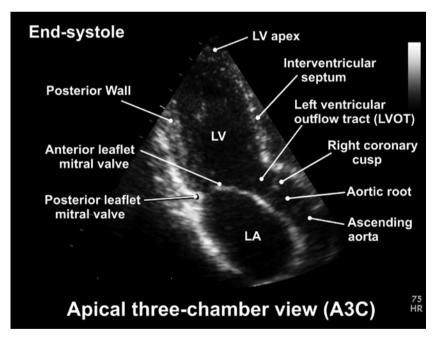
Annotated apical three-chamber view (A3C). (See companion DVD.)
